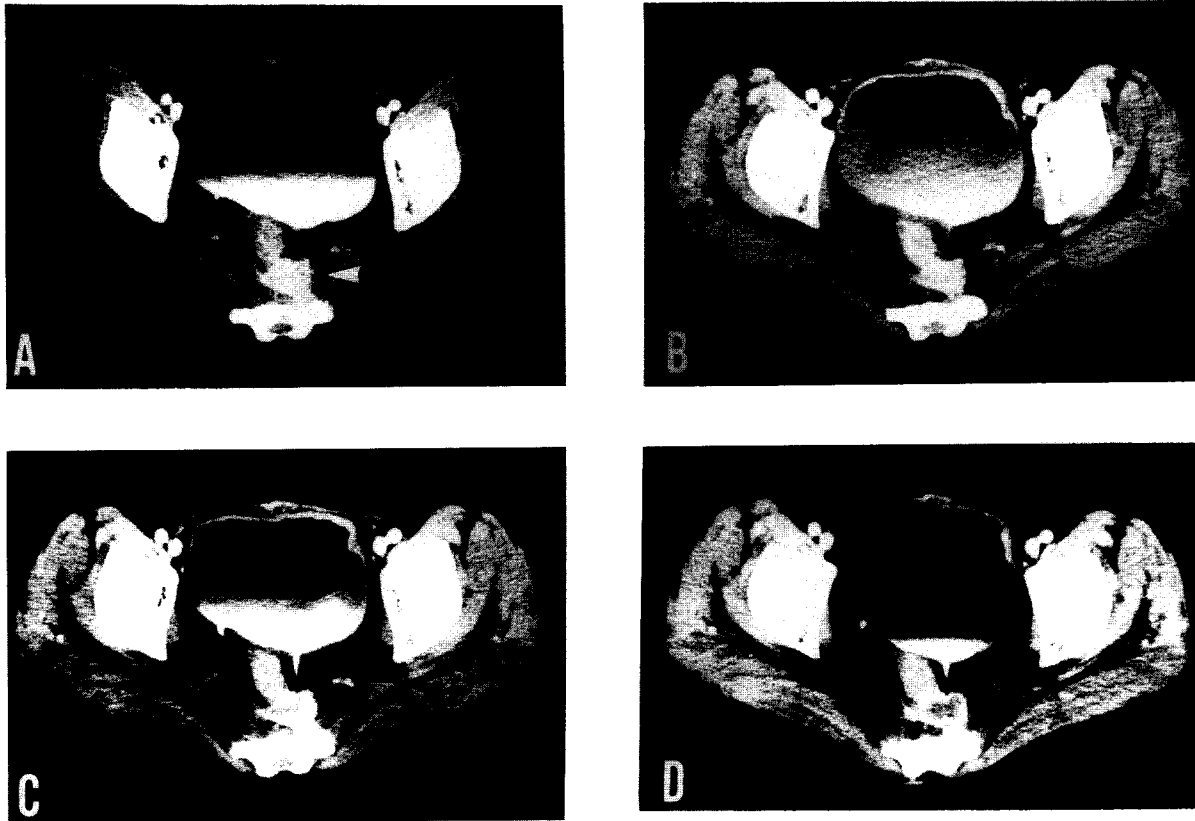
CT of case No. 6. A; Before treatment. Arrow head indicates the recurrent tumor. B; Immediately after treatment. C; 1 month after treatment. D; 3 months after treatment.
